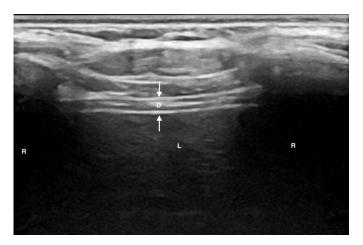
Diaphragm on longitudinal-plane ultrasonography. (D: diaphragm, L: liver, R: rib).
